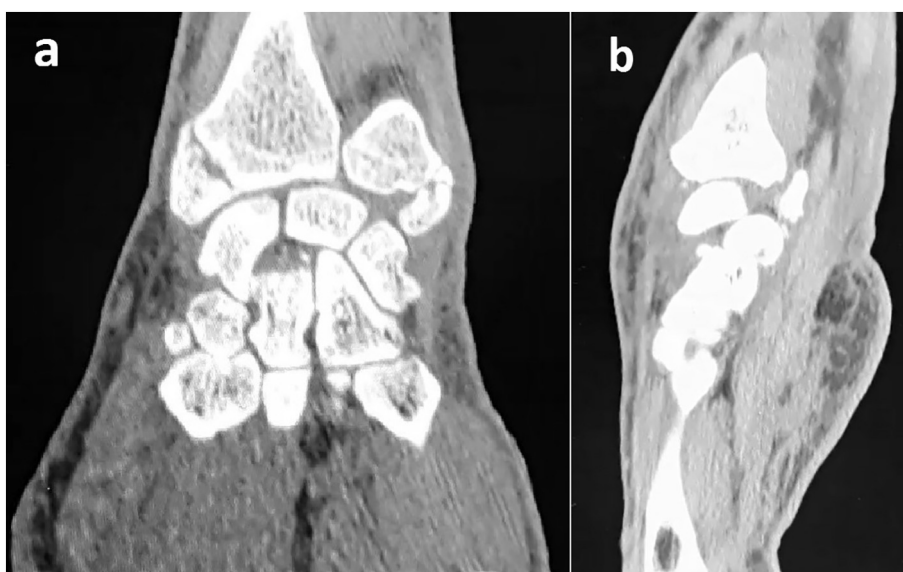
CT aspects in frontal (a) and sagittal (b) sections after closed reduction.
